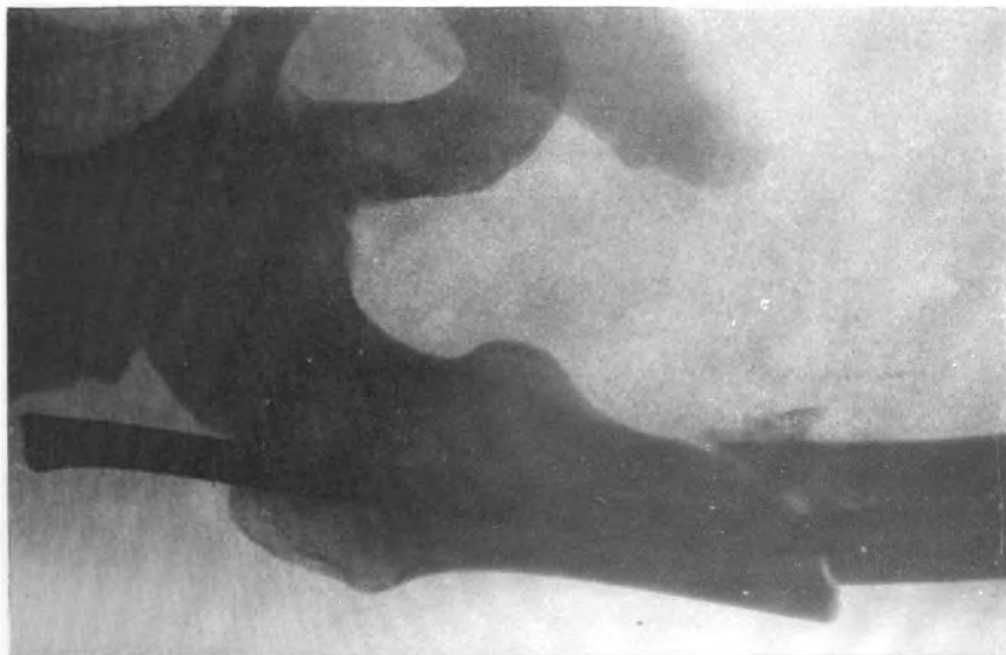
Case 3. Postoperative anterior-posterior x-ray.
